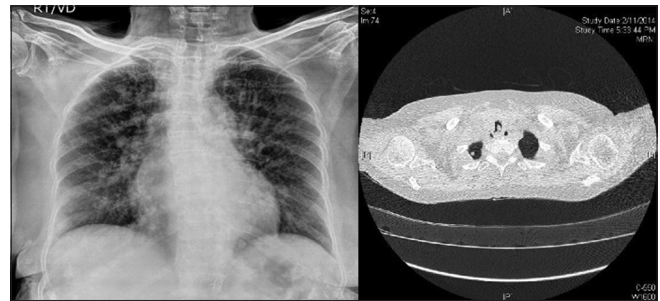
Chest X-ray shows prominent bronchovascular marking, and computed tomography section shows growth in the upper trachea
